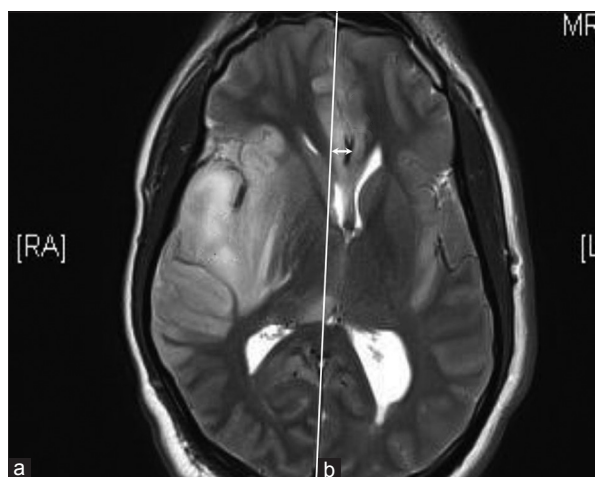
Magnetic resonance imaging of brain: T2-weighted sequence showing swollen and edematous right temporal lobe (a) with mass effect (b) and midline shift as indicated by the arrow
